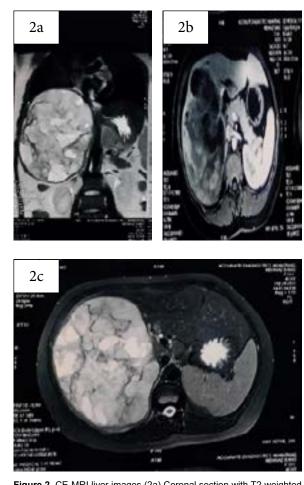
CE-MRI liver images (2a) Coronal section with T2 weighted image showing the large lesion replacing the entire right lobe of liver, (2b) Axial T1 post contrast fat saturated image of the same lesion, (2c) Axial T2 fat suppressed fast recovery sequence showing the heteroge-neity of the lesion
